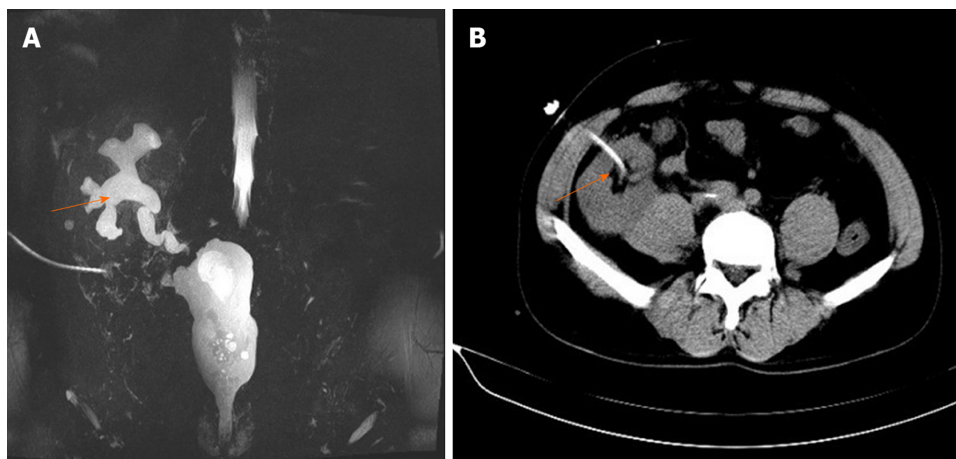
Magnetic resonance urography. A: Magnetic resonance urography show mild hydronephrosis in the graft kidney at 6 mo postoperation (orange arrow); B: Graft percutaneous nephrostomy was performed under ultrasonographic guidance for urinary diversion (orange arrow).
